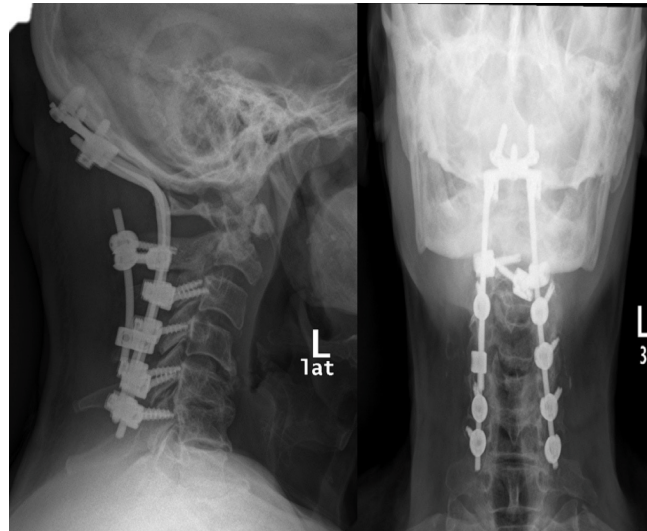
Radiographs showing good alignment, stability, and recalcification of C1 and C2.
